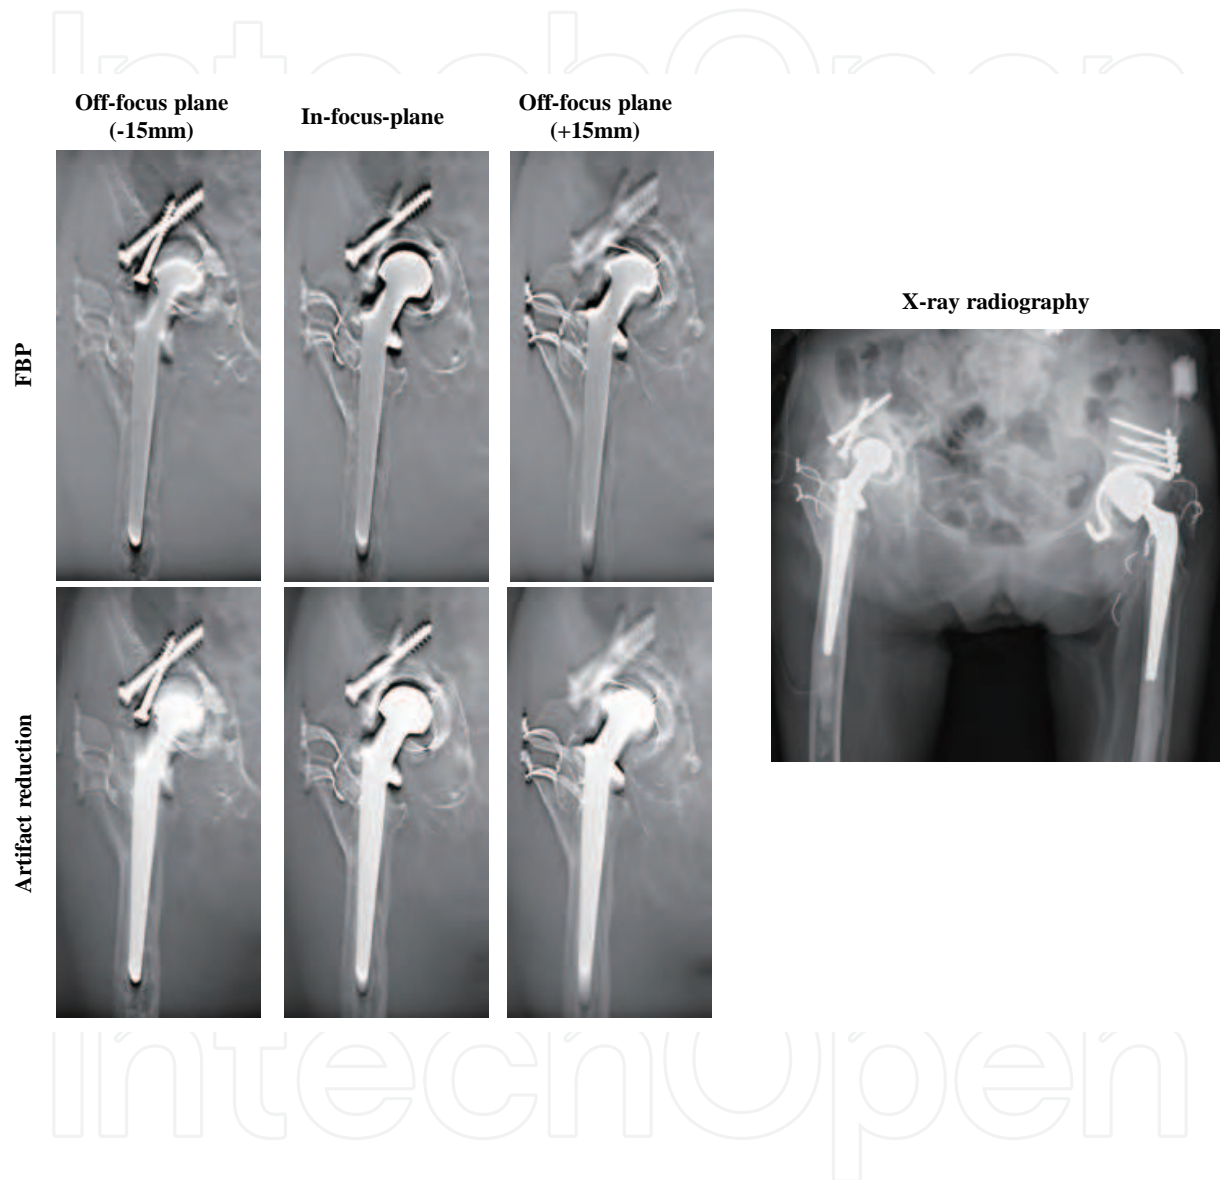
Case 1 patient (81-year-old woman; Rheumatism, post THA). AP radiographs of the hip joint prostheses are demonstrated. AP radiograph is difficult to visualize 3D information in an AP radiograph as shown. The use of artifact reduction tomosynthesis ($w=0.06$) allowed better visualization of the right hip joint prosthesis caused by the blurring of anatomic structures above and below the visualized planes.
